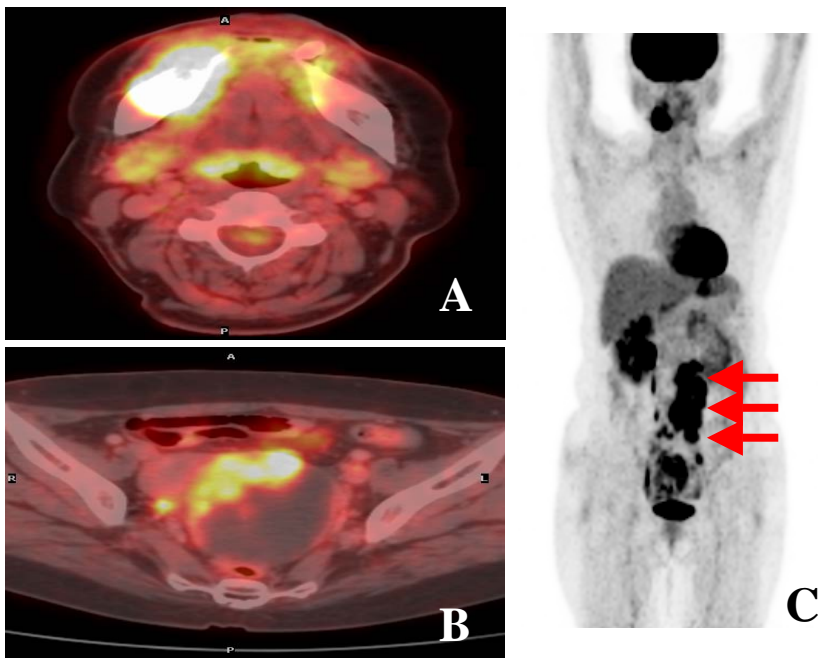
A PET/contrast-enhanced CT showing strong accumulation corresponding to the osteolytic area in the right mandible (A), a PET/contrast-enhanced CT showing strong accumulation (SUVmax = 9.7) corresponding to the enhanced part of the pelvic cystic tumor (B), and a PET image (maximum intensity projection image) showing strong accumulation corresponding to the right mandible, a pelvic tumor, and enlarged pelvic and paraaortic lymph nodes (arrows) (C). PET FDP uptake in tumor is colored in white and yellow.
